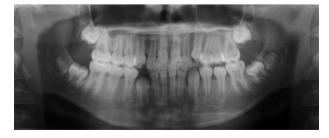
Panoramic radiograph 5 years after surgery. The tumor cavity disappeared; the left mandibular second premolar and first molar, which had deviated due to the tumor, erupted to their normal locations; the left mandibular second molar moved in a normal direction.
